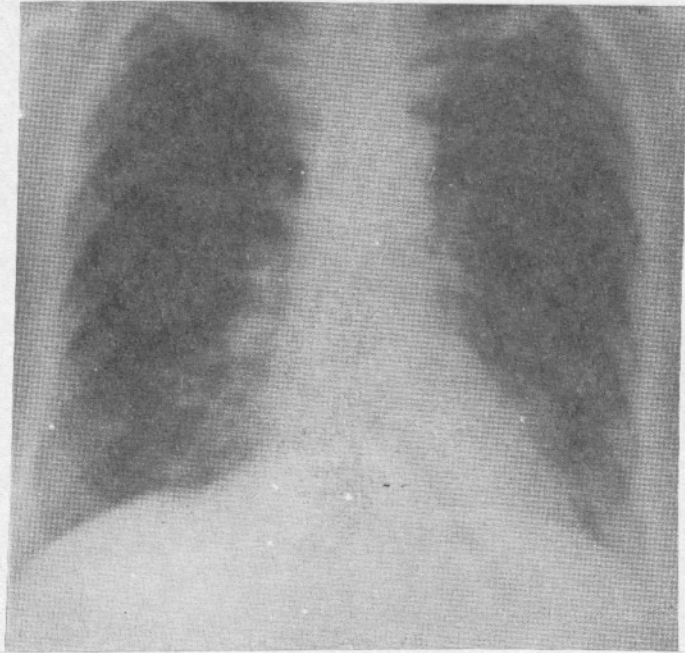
Chest X-ray of the patient, after the pericardial drainage.
